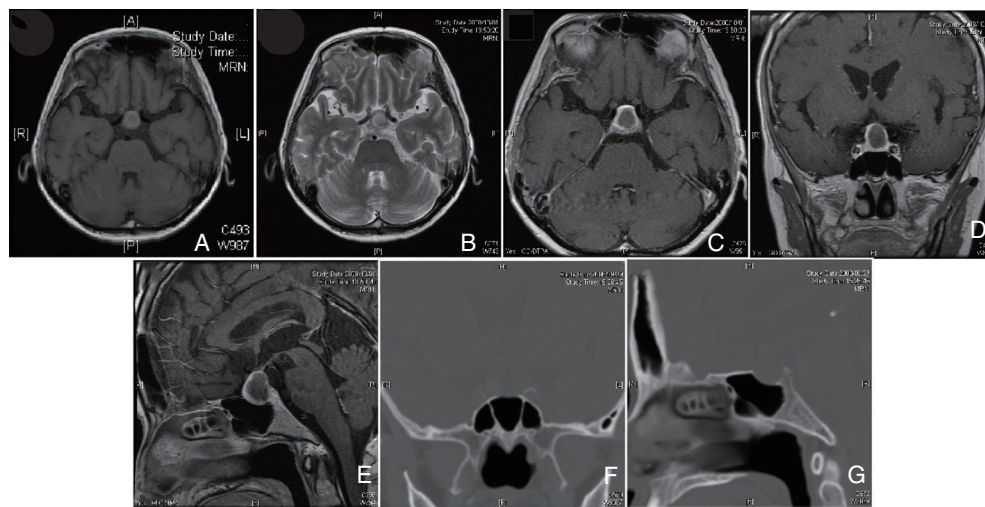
Preoperative MRI and CT findings. Preoperative plain MRI showing iso-intensity on T₁-weighted image (A) and high-intensity on T₂-weighted image (B). An axial section (C), a coronal section (D), and a sagittal section (E) of contrast-enhanced MRI showing rim-enhancement of the tumor. A coronal section (F) and a sagittal section (G) of preoperative bone CT showing intact paranasal sinuses and clivus. MRI: magnetic resonance imaging, CT: computed tomography.
